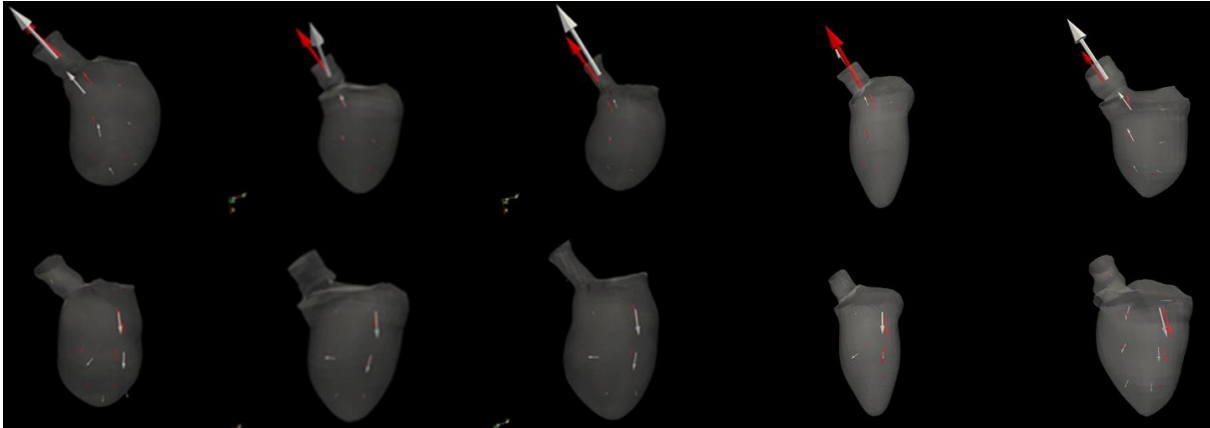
Regional velocity comparison between CFD (red) and PC-MRI (white) for five OPBG patients. Peak systole is shown on the top and peak diastole is shown on the bottom. The mean differences are 6cm/s for both peak systole and diastole.
